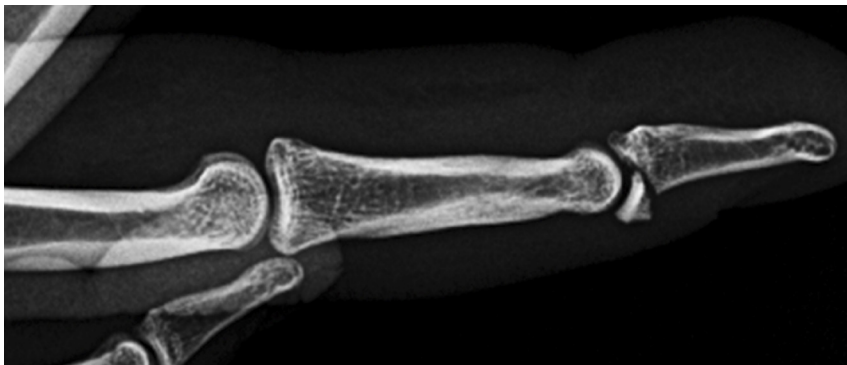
Type 1B Mallet Finger Injury Lateral X-Ray.
